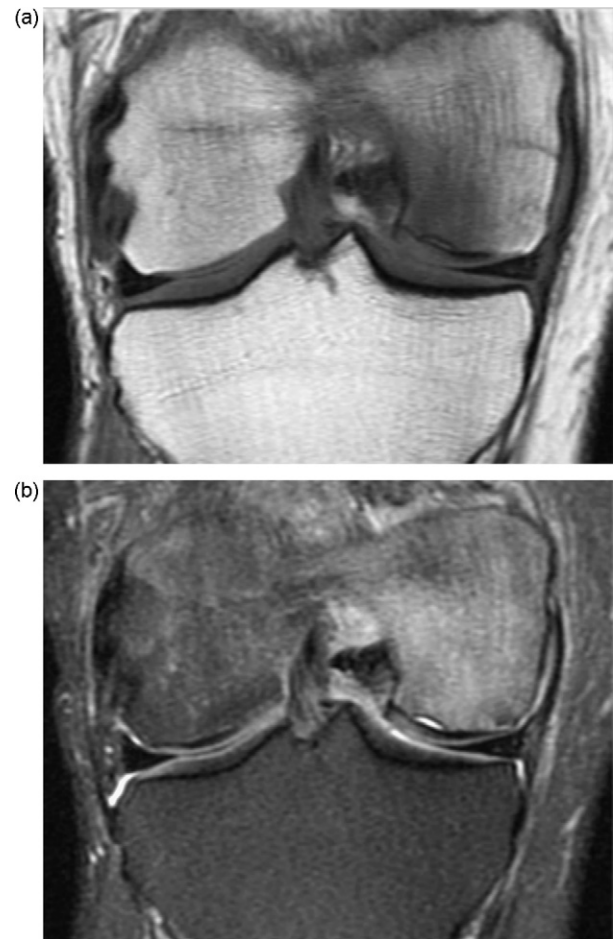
MR images of the knee in a 59-year-old male with instability and acute knee pain. (a) Coronal T1-weighted image shows dark signal replacing the marrow in the medial femoral condyle. A small subchondral fracture is seen. (b) Coronal T2-weighted image with fat saturation shows edema in the medial femoral condyle. A fluid filled cleft (fracture) is seen in the subchondral bone with intact adjacent cartilage (arrow).
